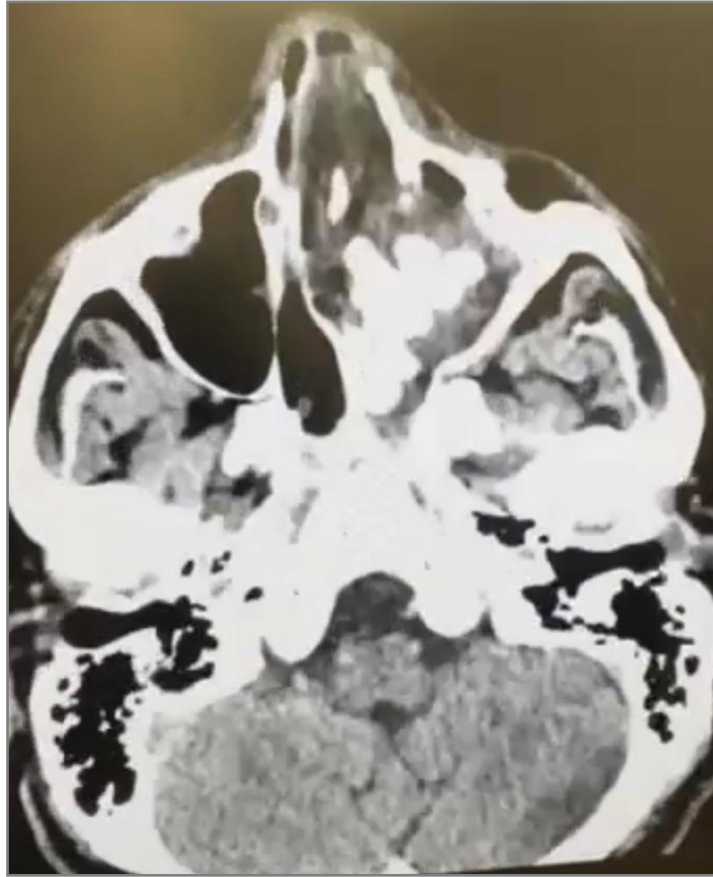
CT scan (axial section) of a patient with CRS, with rhinoliths due to working in an environment with occupational hazards.
